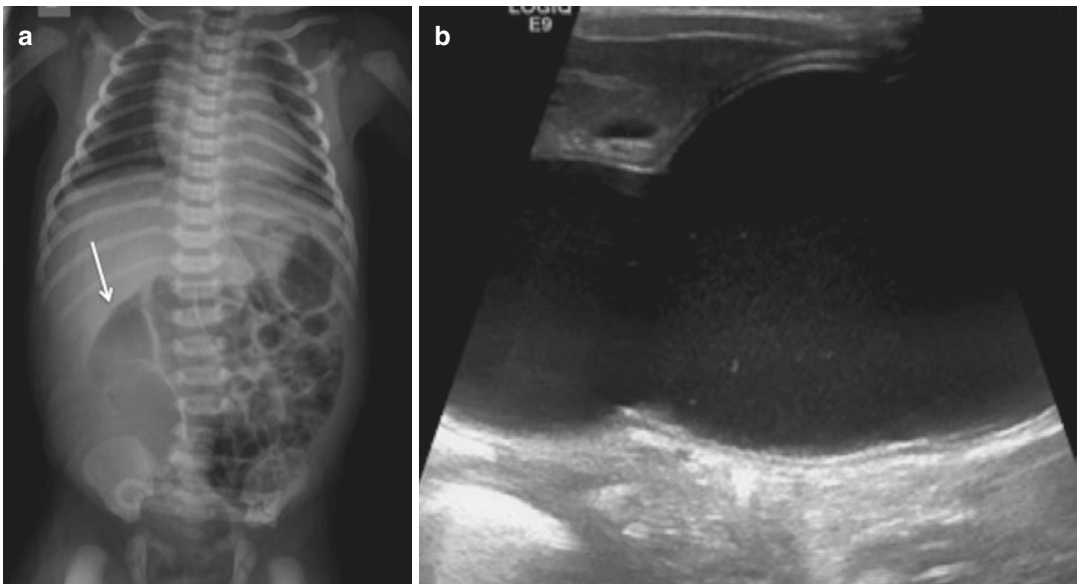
Neonatal digestive occlusion by a tubular duplication cyst. (a) Abdominal radiograph shows a distended loop in the right flank (*arrow*) and evidence for intestinal occlusion. (b) The US performed at the same time shows a typical multilayered walled cystic structure corresponding to a duplication cyst responsible for the occlusion
